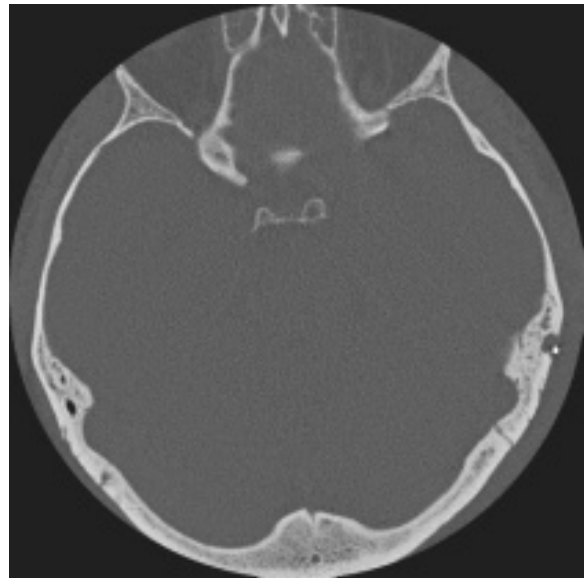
High-resolution CT scan 2 days later. Pneumocephalus is no longer present.
